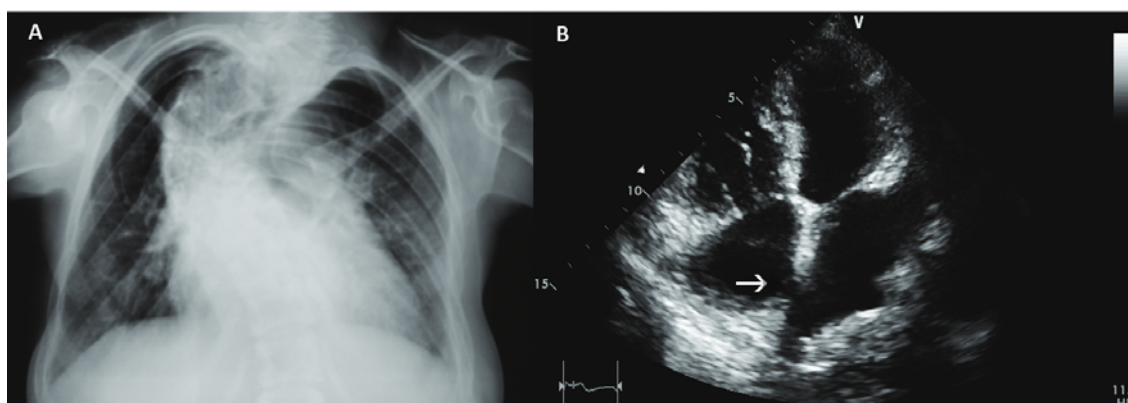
A) Chest x-ray showing the enlarged cardiac silhouette and severe kyphoscoliosis; B) Transthoracic echocardiogram showing atrial septal defect (arrow).
